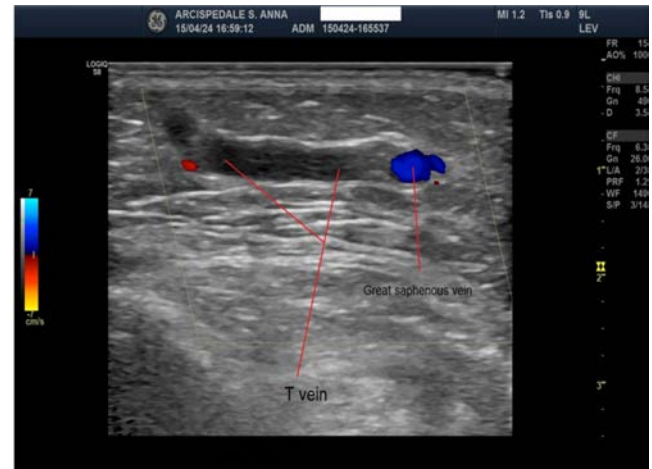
Ultrasound transversal duplex image documenting the origin of the T vein from the Great Saphenous Vein (GSV) and its perpendicular course towards the tibial region.
